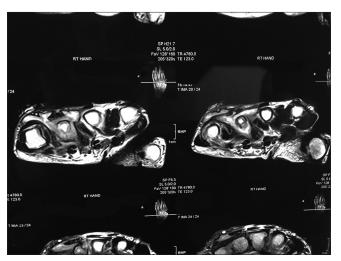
Magnetic resonance imaging of the right hand showing destruction of the four metacarpal bones with surrounding edema
